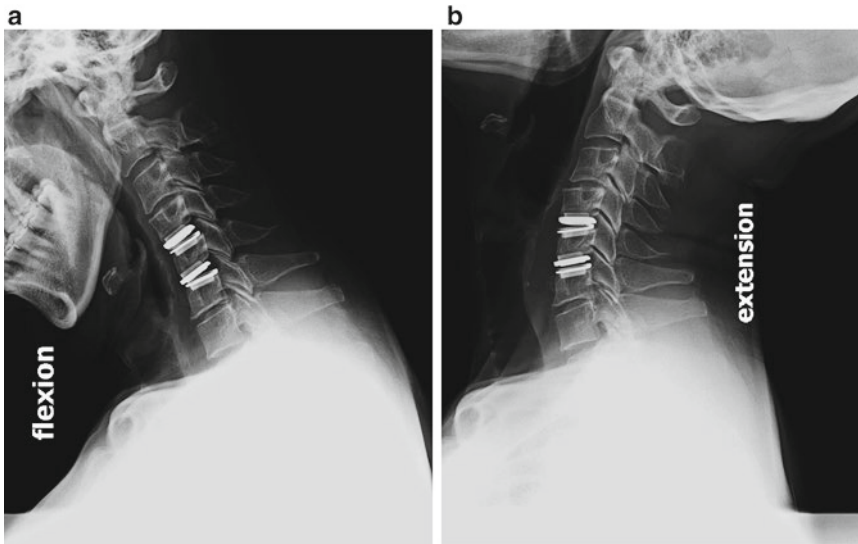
(a) Flexion radiographs after C4-C5 and C5-C6 total disc replacement. (b) Extension radiographs after C4-C5 and C5-C6 total disc replacement. Excellent motion at both levels is present
